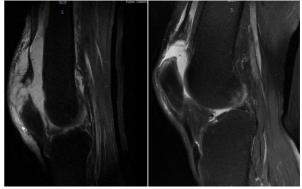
Preoperative sagittal T2-weighted magnetic resonance images of the right (A) and left (B) knees showing complete disruption at the distal quadriceps tendo-osseous junctions (arrow).
